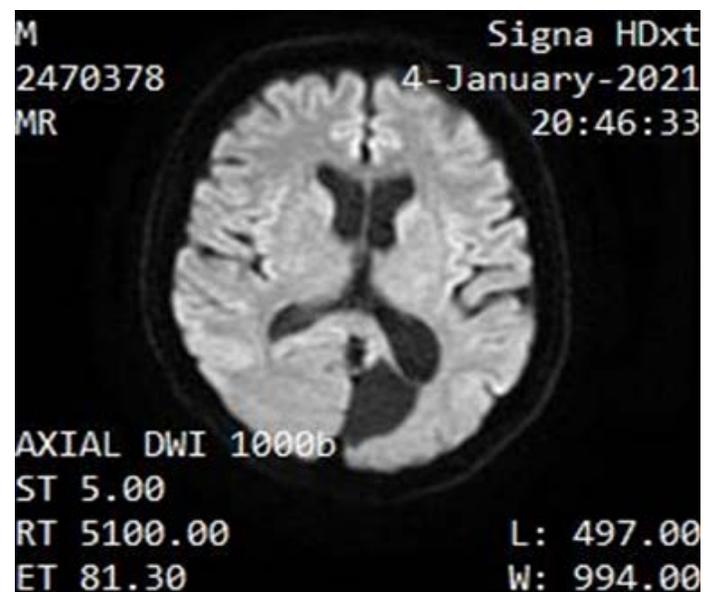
The appearance of a Porencephalic cyst in left temporal occipital region of size 3.6x2.7x2.7 in MR imaging
